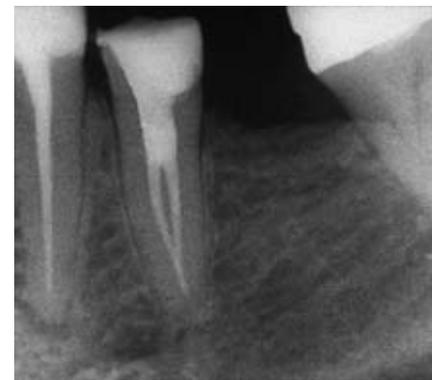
Mandibular 2nd premolar: the abrupt loss of canal visibility on the radiograph can indicate a dividing of the main canal.
